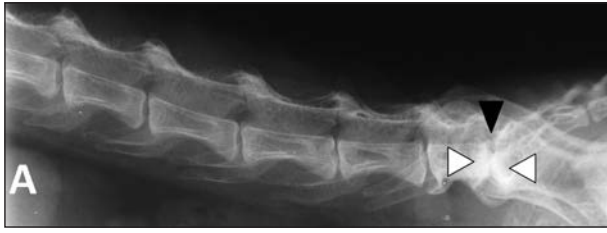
Same radiographic images as in Figure 1. A—Note the subluxation of the L7-S1 junction (black arrowhead) and sclerosis of the L7 and S1 end plates (white arrowheads) with collapse of the L7-S1 intervertebral disk space. B—Note the sclerosis of the L7 and S1 end plates (white arrowheads).
